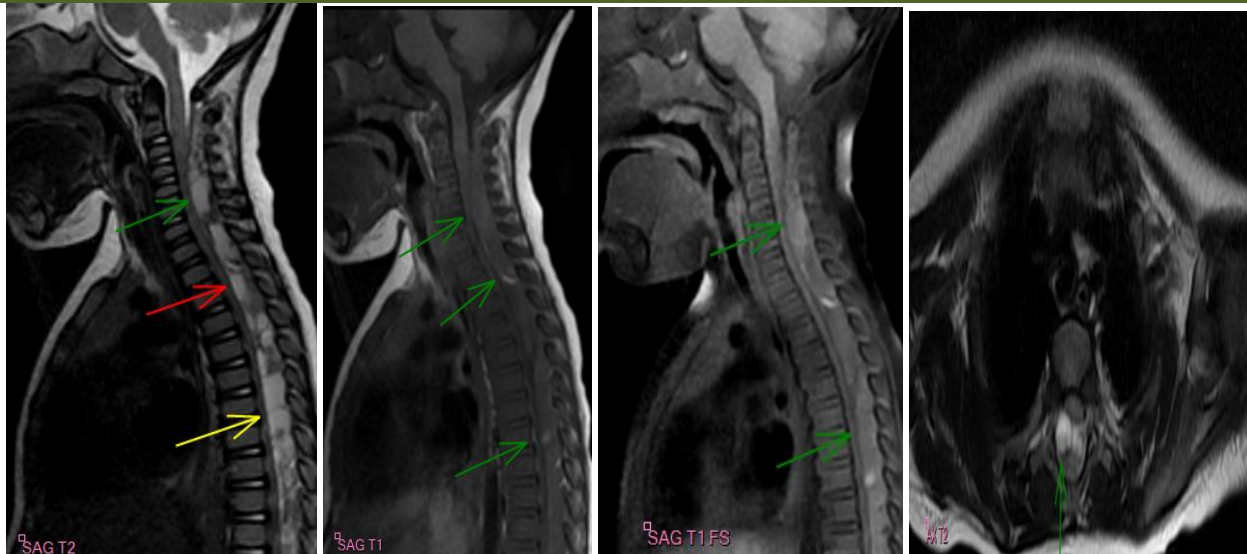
Spinal MRI with sagittal T1, T2 and T1FS images, and axial T2 images showing a large epidural hematoma extending throughout the cervical, thoracic and lumbar spine (from C1 to L5), appearing isointense on T1 and hyperintense on T2, containing areas of marked T2 hypointense signal and other areas of T1 hyperintense signal; following gadolinium injection, adjacent meningeal enhancement is noted; the whole complex is responsible for spinal cord compression at this level with signs of spinal cord injury at the C4-C5 level
